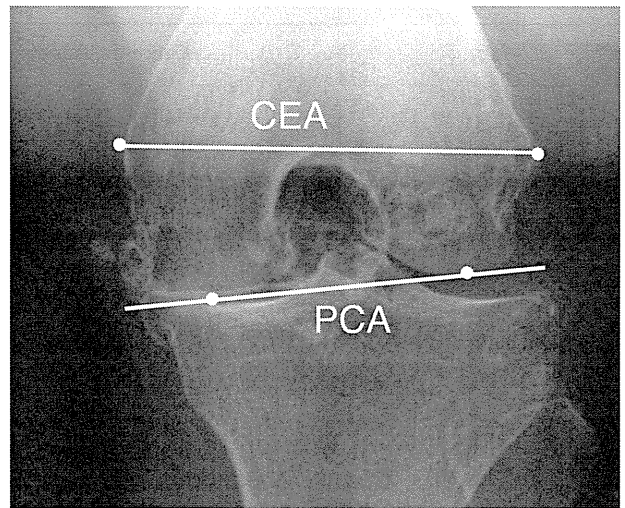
Axial radiograph of the distal femur taken by the method of Kanekasu et al. [17]. CEA is the line connecting the medial and lateral epicondylar prominences; PCA is the line connecting the posterior margins of the medial and lateral femoral condyles.
